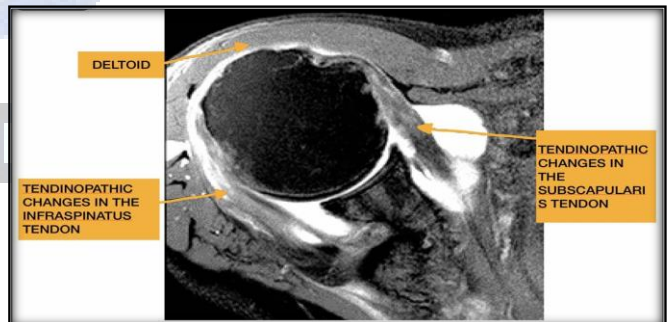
A 57 year old male with right shoulder pain, diagnosed to have tendinopathic changes of infraspinatus. Image - MRI- Proton Density fat suppressed Image, axial section showing tendinopathic changes of infraspinatus with associated tendinopathic changes in subscapularis tendon.
